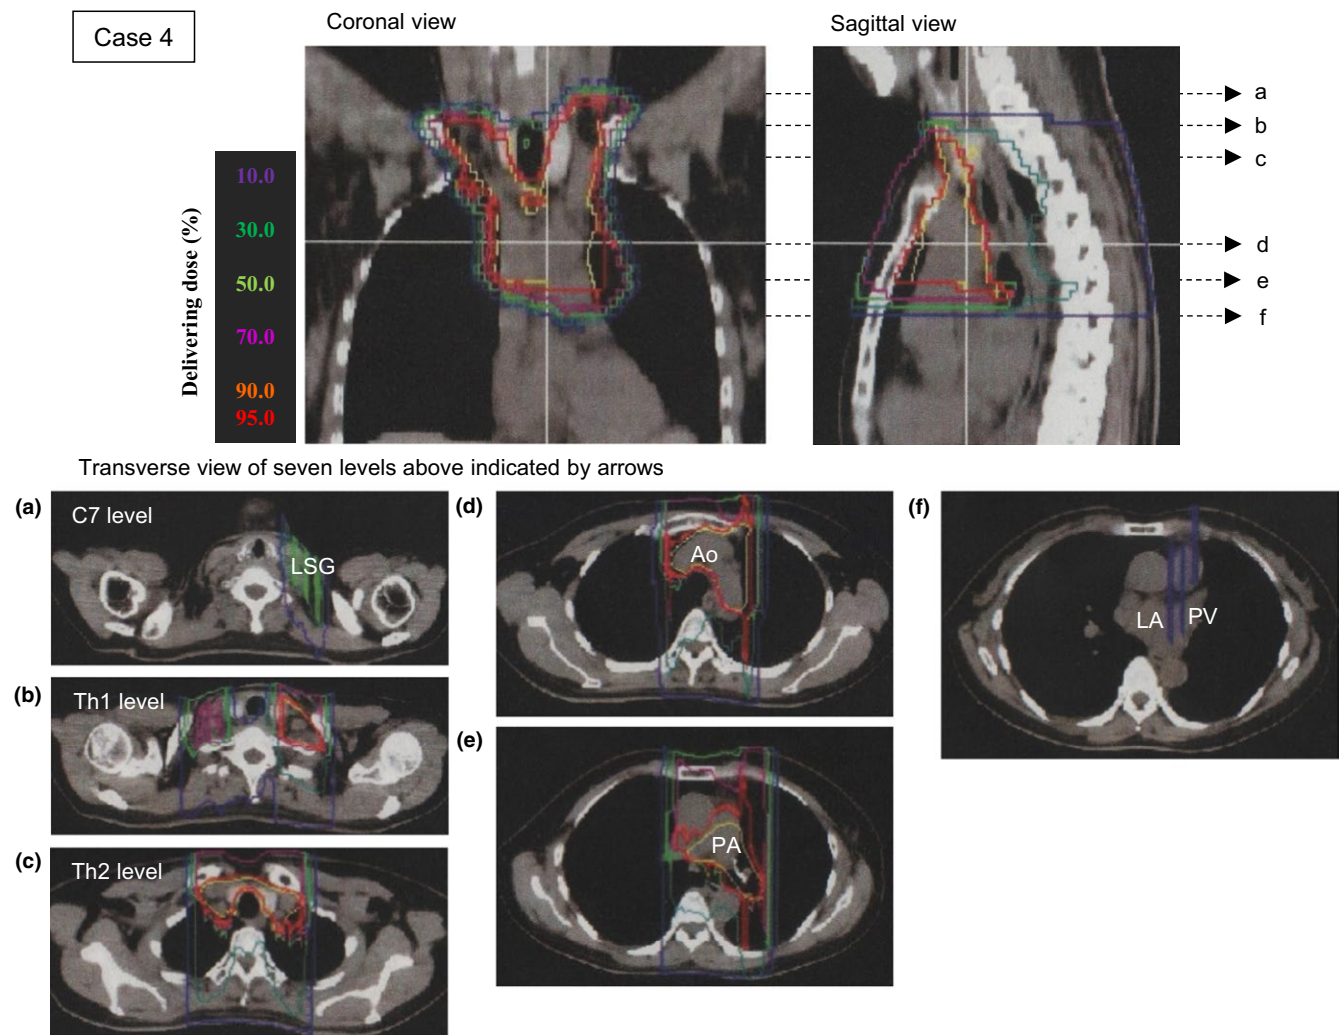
Radiotherapy for the superior mediastinum lymph nodes of Case 4 was planned using computed tomography (CT) images. The dose planning images shown are the coronal section, sagittal section, and horizontal section. Six horizontal sections were extracted at the levels of: (a) the seventh cervical vertebra (C7) including the left stellate ganglion (LSG); (b) the first thoracic vertebra (Th1); (c) the second thoracic vertebra (Th2); (d) the aortic (Ao) arch; (e) the pulmonary artery (PA) bifurcation; and (f) the left atrium (LA) with the left pulmonary vein (PV). The estimated delivery dose was drawn on the radiation therapy planning CT images using isodose lines: 10% violet, 30% green, 50% yellow-green, 70% magenta, 90% orange-red, and 95% red
